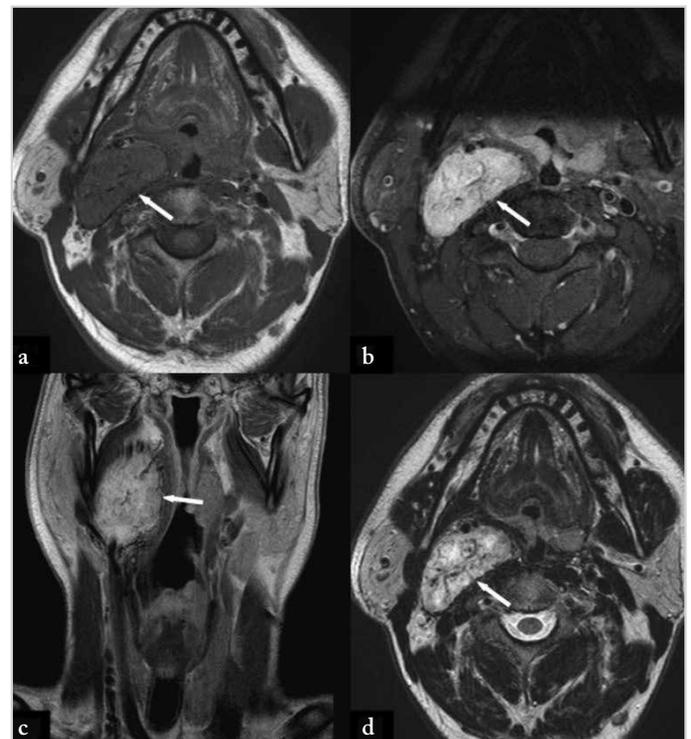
Axial T1- (a) and axial T2-weighted (b) without contrast and coronal (c) T1-weighted with contrast and axial (d) T1-weighted with contrast MR images of a 45-year-old female patient revealed right parapharyngeal glomus vagale (white arrows)
